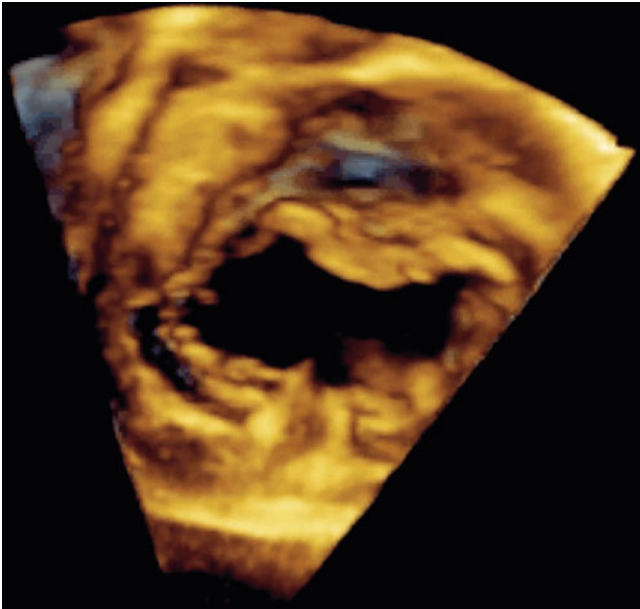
Three-dimensional image obtained by transesophageal echocardiography in an older child displaying *en face* view of a complete atrioventricular septal defect. Note the detailed definition of the common atrioventricular valve components (Image by courtesy of David A. Roberson, M.D.)
